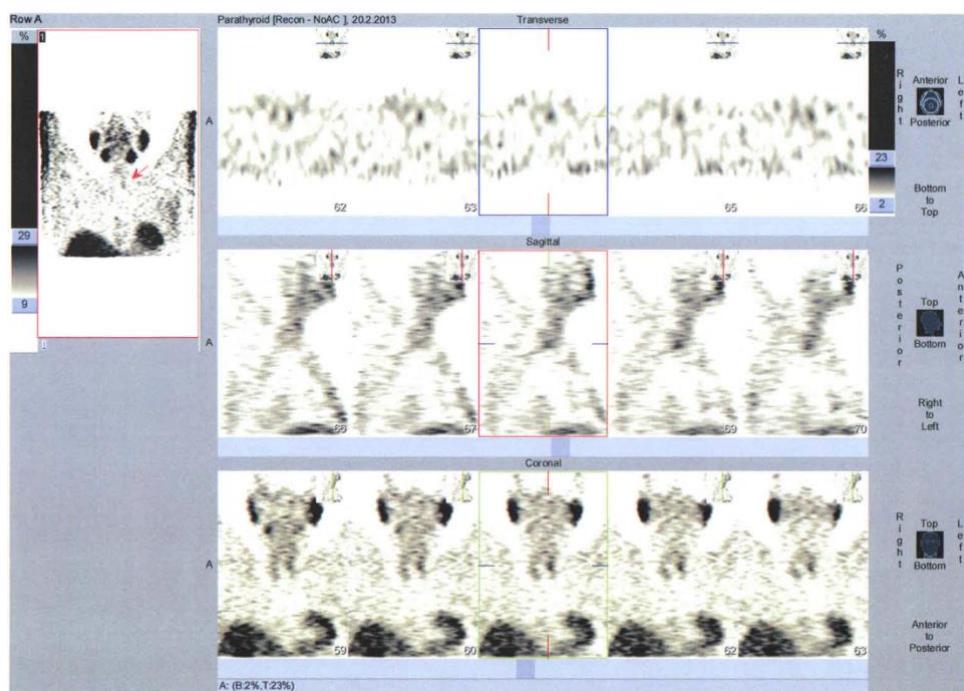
Early SPECT images – a hyperfixating zone is registered in the caudal part of the left thyroid lobe, suspicious for parathyroid adenoma
